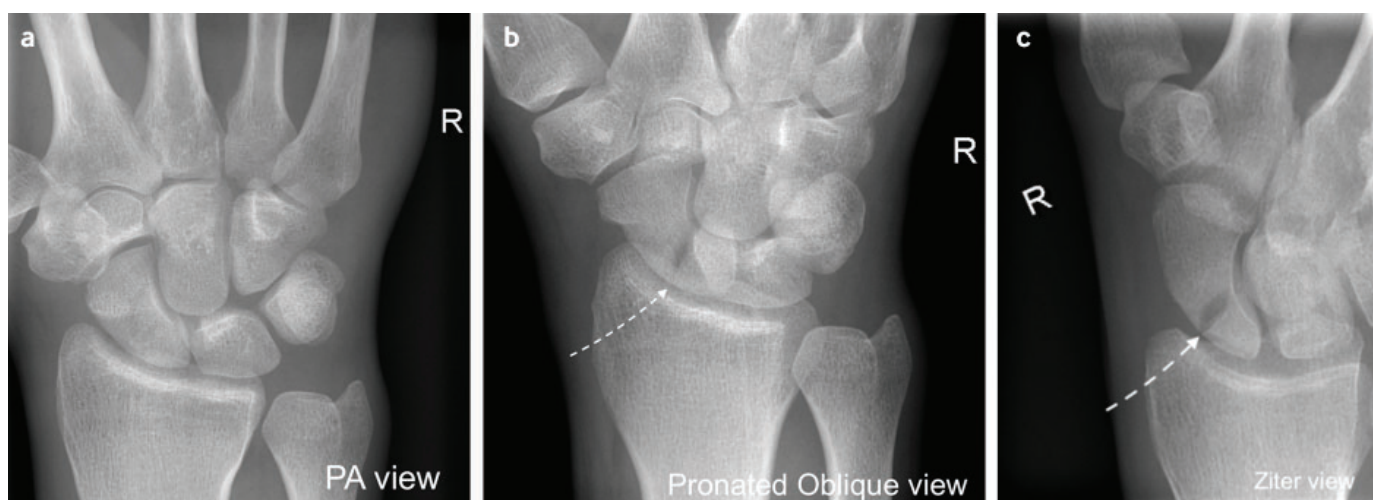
Scaphoid views performed six weeks after the injury. Three of the standard scaphoid series are presented including (a) posteroanterior, (b) pronated oblique, and (c) Ziter views. A proximal pole fracture is clearly seen on the pronated oblique and the Ziter views. The fracture is still not visible on the posteroanterior view, similar to the equivalent radiograph taken at day 1 (fig 1a). Arrow indicates fracture site
